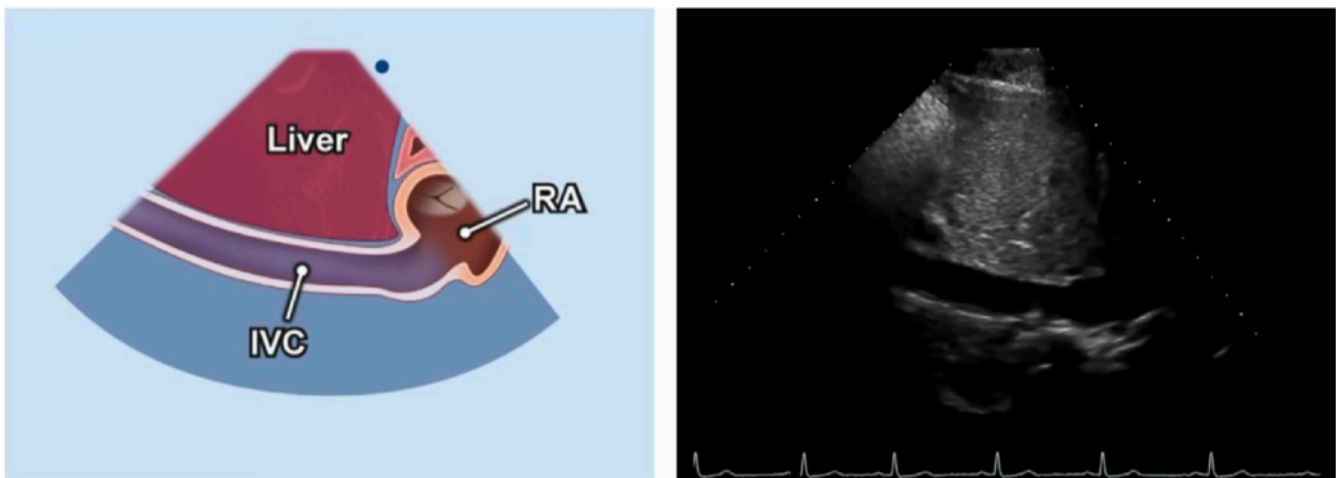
Subcostal ultrasound view demonstrating the inferior vena cava entering the right atrium.
